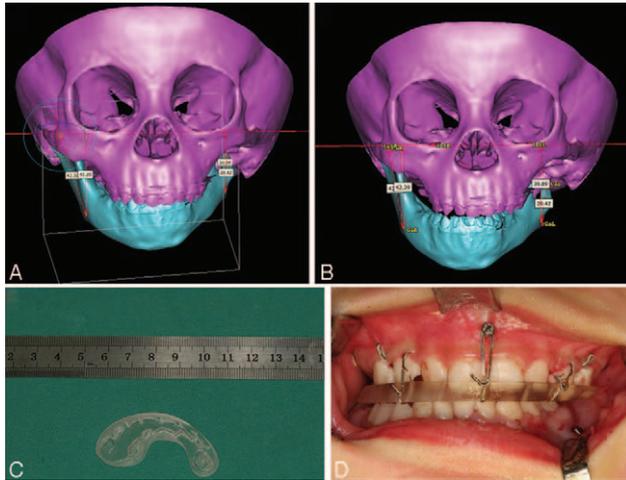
Three-dimensional computer-aided surgical technology was used in the treatment of patient 4 with Pruzansky/Kaban type IIB mandibular hypoplasia to improve the traditional surgical planning method. A, Precise digital dental models made by scanning the plaster dental models were incorporated into a three-dimensional computed tomographic scan of the patient's maxillofacial region. Then, the distance between the gonion and Frankfort plane was measured. B, The mandible was moved and rotated to the desired position to achieve symmetrical bilateral gonion. C, Surgical occlusal splint was prefabricated by computer-aided design/computer-aided manufacturing techniques. D, Accurate surgical occlusal splints enabled transfer of the surgical plan to the patient at surgery.
